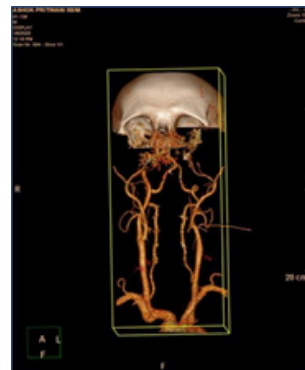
CTA Showing Complete Occlusion Of Left ICA From Origin.
